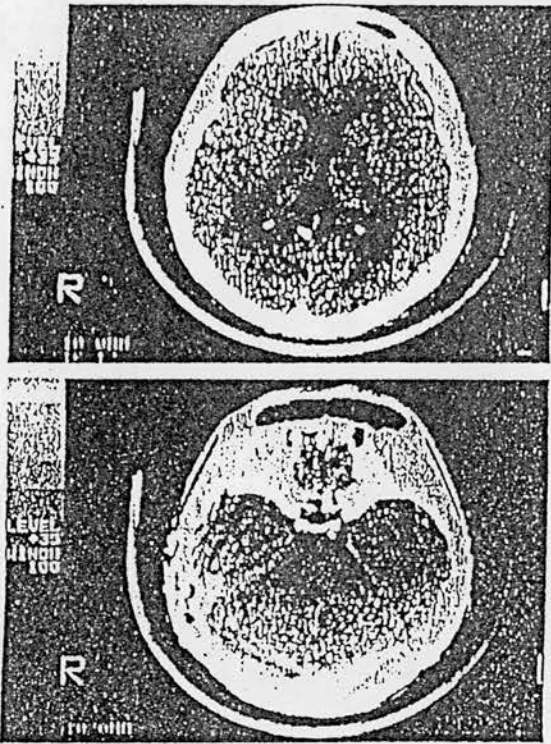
Cerebral CT showing further lesions including a locus of calcification behind the posterior clinoid process.
